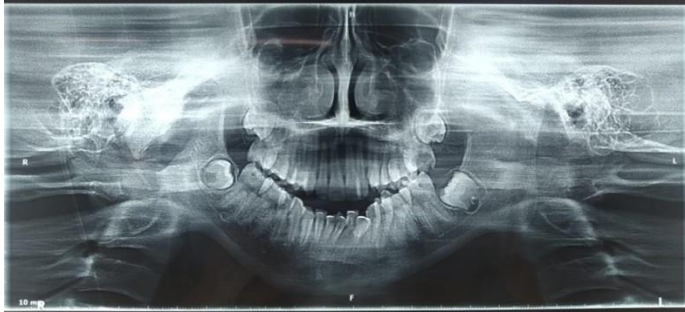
Preoperative orthopantomogram (OPG) showing Right side TMJ ankylosis.
